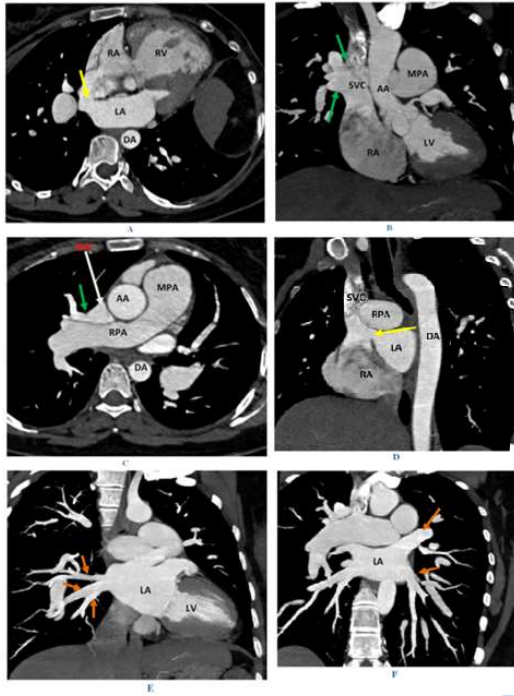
CT Cardiac findings
